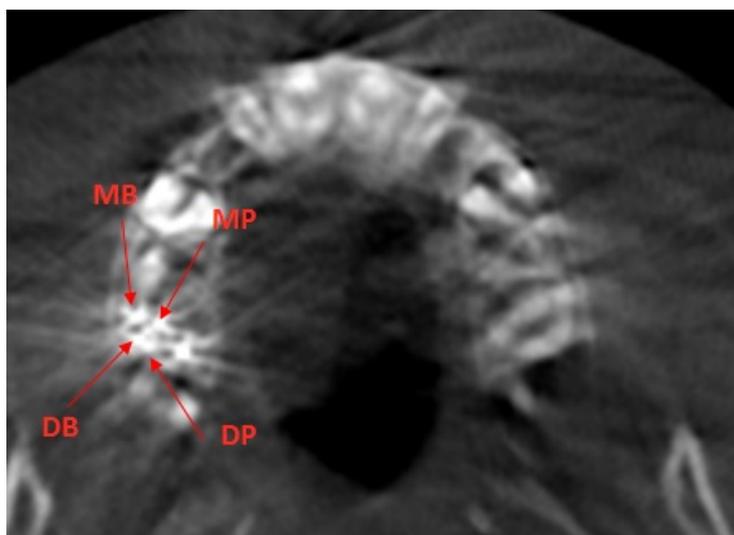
CBCT view of the maxillary right molar at coronal third.
